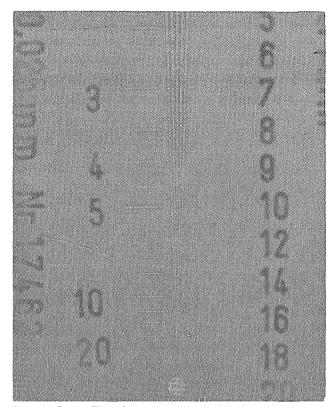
(a). This image of a lead test target was made on Kodak ultraspeed film using 90 kVp X-rays and standard processing conditions. With magnification, one can resolve 20 line pairs per millimeter.
